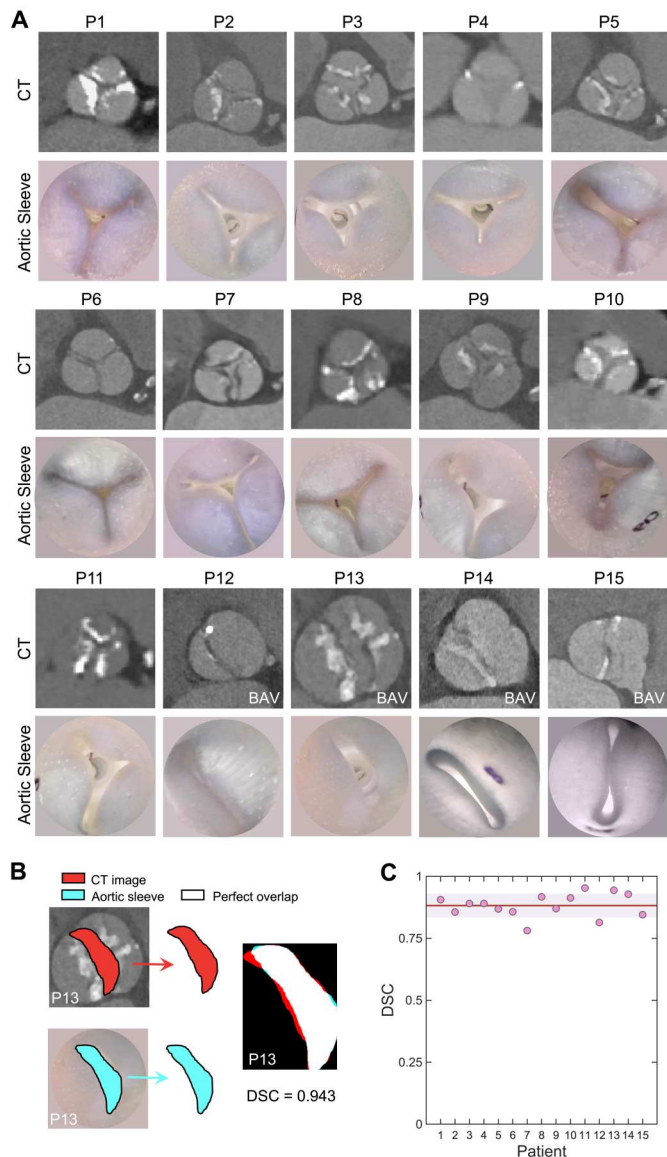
Morphologic mimicry of the aortic valve defect for both degenerative AS and BAV. (A) Top row: Images of the aortic valve from CT data (patients 1 to 15). Bottom row: Aortic lumen in the model during aortic sleeve actuation. All images taken at peak systole. (B) Representative CT and aortic sleeve luminal images (patient 13) for calculation of the DSC. (C) DSC for all patients. The red line in the graph denotes the average DSC across the patient population, and the shaded area shows ± 1 SD.
